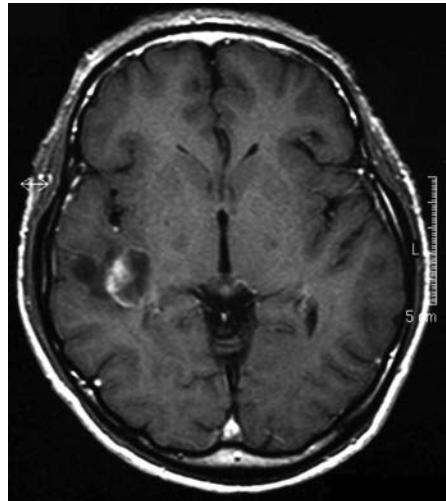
MRI of papillary glioneuronal tumour presenting as a multicystic tumour with a gadolinium-enhanced solid component in the right temporal lobe.
